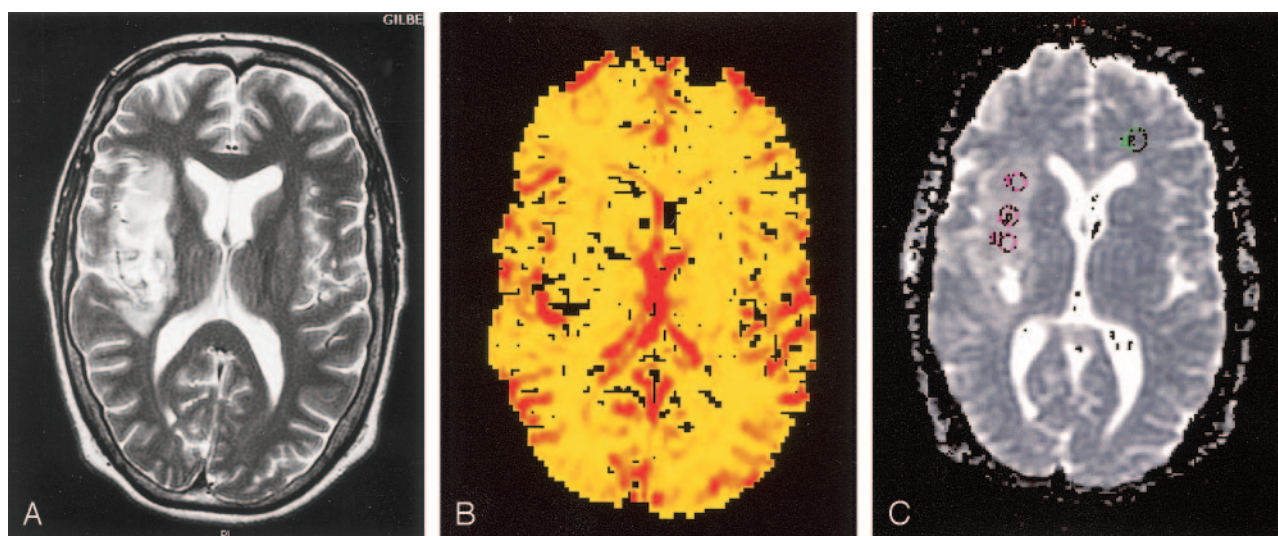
MR imaging study following four cycles of chemotherapy with PCV.
